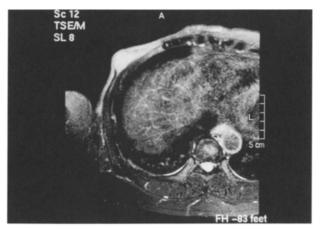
Magnetic resonance imaging revealed a recurrent tumor 25×17 mm with peritumoral invasion.
